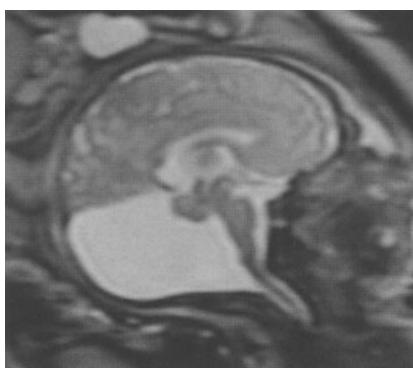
Antenatal diagnosis of Dandy-Walker cyst. Sagittal T2-weighted image shows ventricular dilatation and fourth ventricular enlargement
